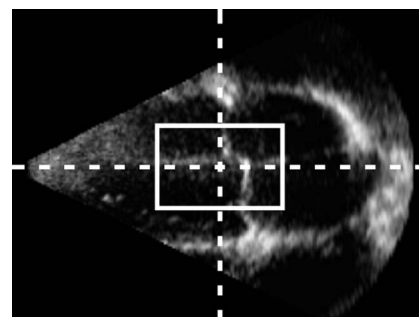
Rectangular region defined in the apical 4C image.
